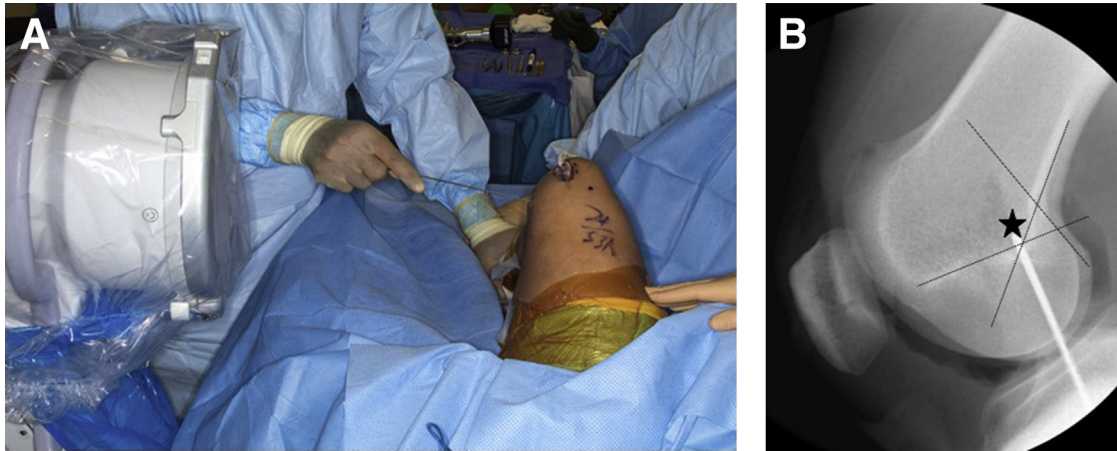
(A) Once the femoral incision is dissected down to the medial epicondyle, the knee is flexed to approximately 90° and fluoroscopy is used to isolate the Schöttle point on a perfect lateral radiograph. (B) This point (star) is located approximately 1 mm anterior to the posterior cortex of the femur, 2.5 mm distal to the posterior origin of the medial femoral condyle, and proximal to the posterior point of the Blumensaat line.
